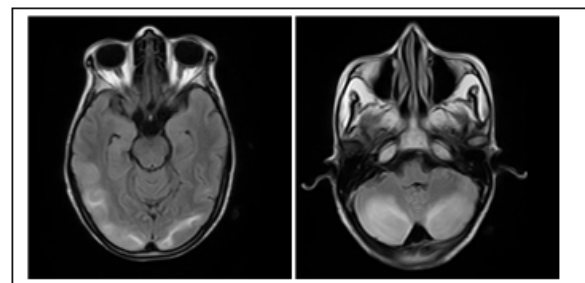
MRI showing hyper intense lesion in bilateral parieto-occipital lobe and cerebellum.
